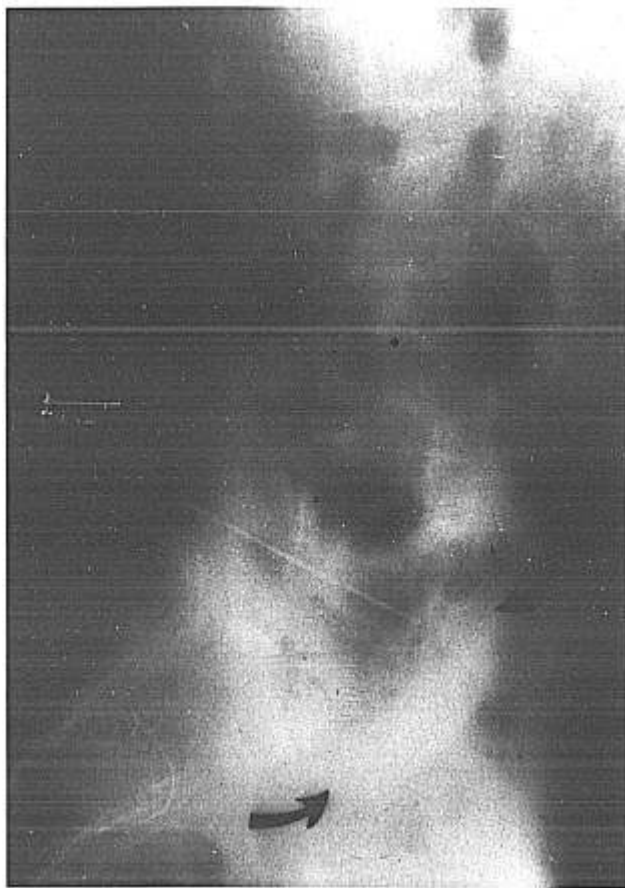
Lateral radiograph demonstrating correct needle placement. Arrows indicates superior and anterior margins of opacity formed by contrast medium (3–4 ml). Note smooth anterior and posterior margins of spread of dye suggesting retroperitoneal placement anterior to the psoas muscle.
